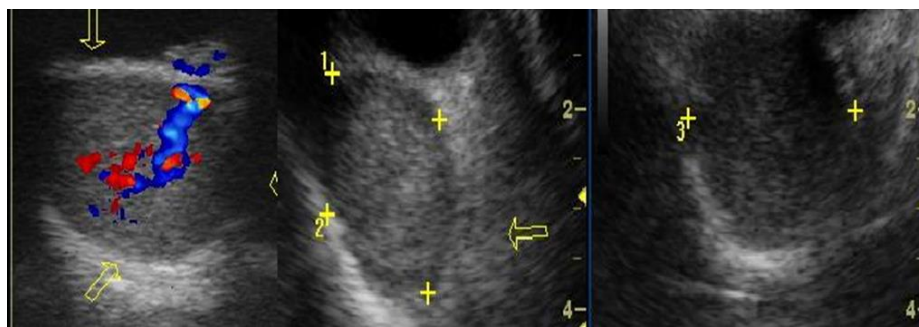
Ultrasound demonstrates a smoothly circumscribed retro bulbar lesion with regular moderate to high internal echogenicity 3-4. No flow can be demonstrated on Doppler scanning
